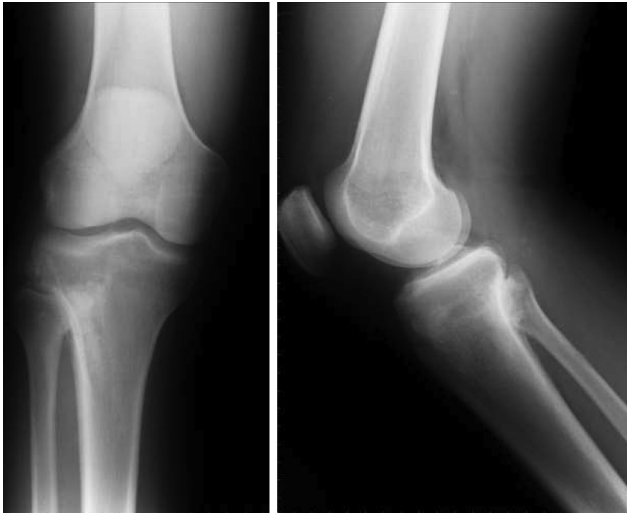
Antero-posterior and lateral plain radiographs show radiolucent lesion of the proximal tibia, near to the tibiofibular articulation.
